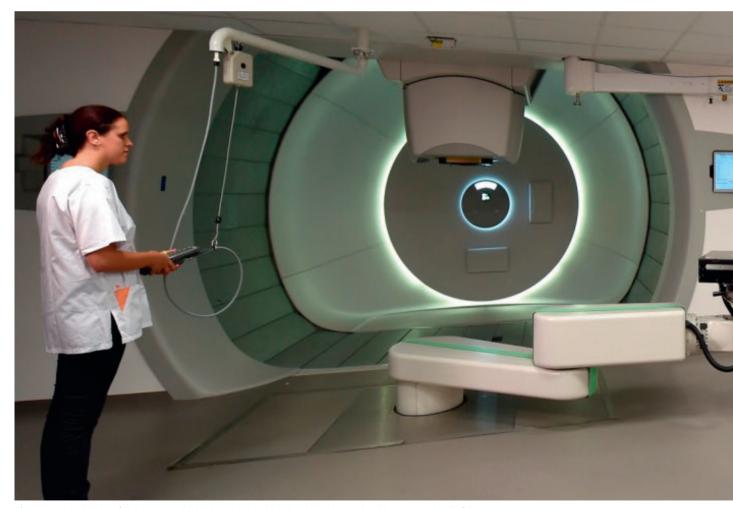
Installation of the in-room CT Sliding Gantry (right) next to the proton therapy gantry (left) in the University Proton Therapy Dresden (Germany).
